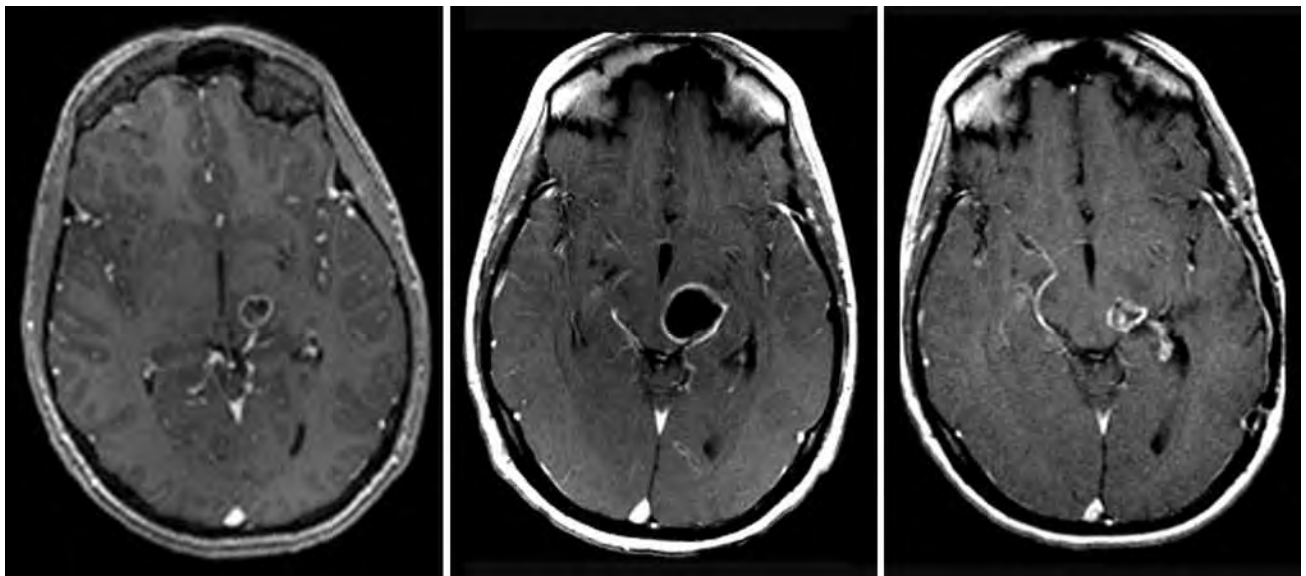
Pseudoprogression after chemoradiation. MRI of a biopsy-proven grade III astrocytoma before treatment (left panel). Three weeks after completion of chemoradiation, there is an increase in the size of the cystic component and enhancement (middle panel), which could be interpreted as tumor progression. After 4 cycles of post-radiation temozolomide, the right panel shows a decrease in size and enhancement, supporting the earlier imaging changes as reflective of pseudoprogression. All images are T1 post gadolinium with a 1.5 Tesla magnet.
